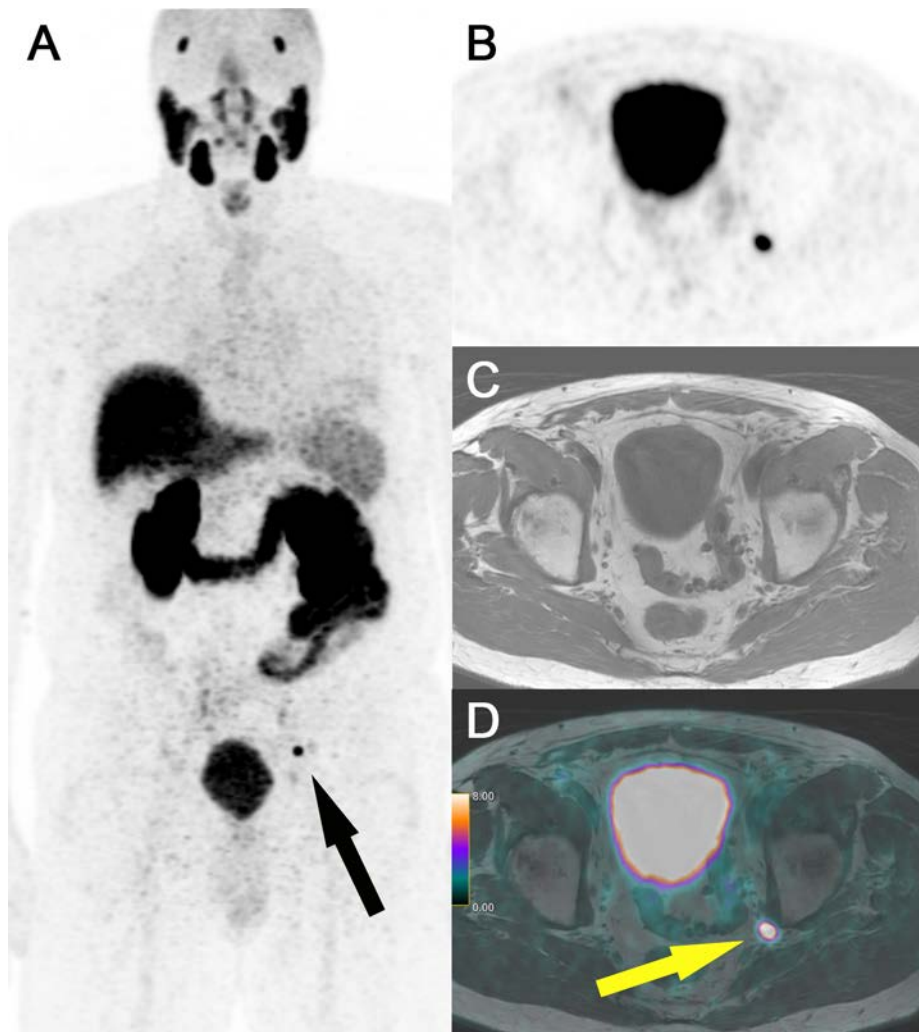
73-year old patient referred to ^{68}Ga -PSMA-11 PET/MRI after prostatectomy for a pT3a, pN0, cM0 Gleason 7 and a rise in PSA to 0.41 ng/ml 3.5 years after prostatectomy. a) Coronal MIP showed solitary intense focal PSMA-uptake in a left internal iliac area (arrow). b) Focal uptake was confirmed on axial PET (SUV_{max} 23), c) corresponding to a non-enlarged lymph node in the left iliac internal region on axial T1-weighted sequence and d) the fused PET/MRI (arrow). Based on the assessment of our radiation oncologist, this finding would change the radiation plan.
